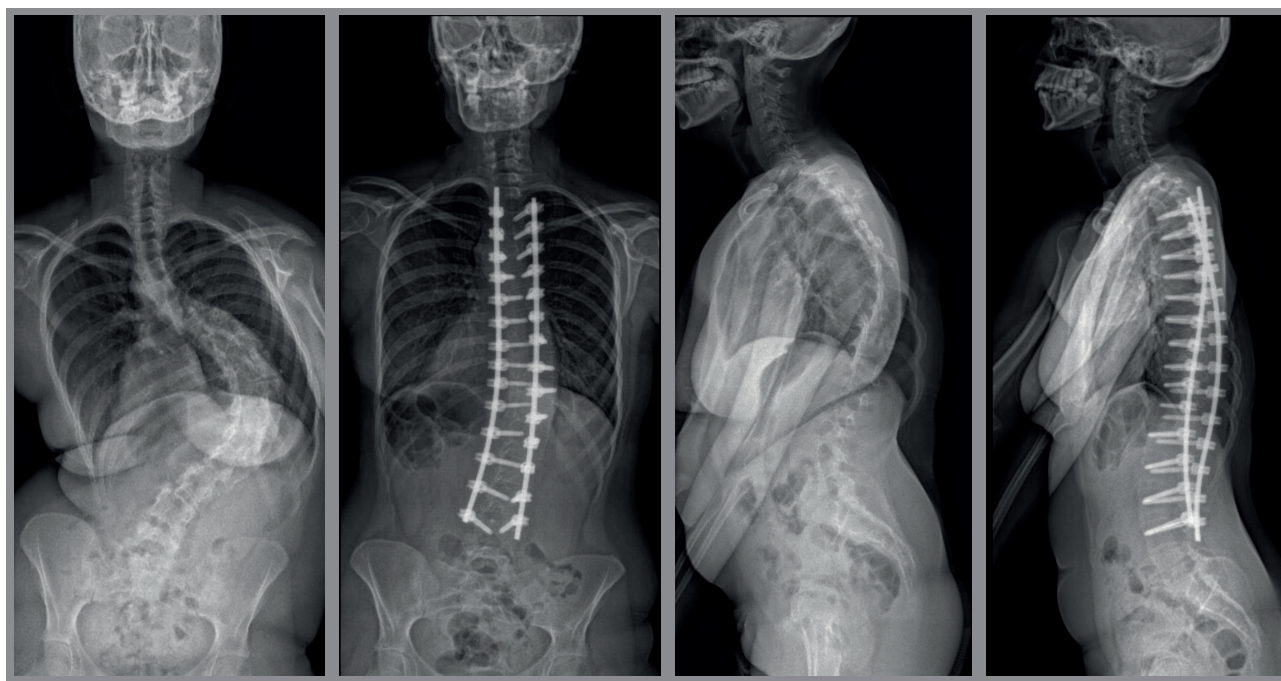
X-rays before and after surgery, Cobb angle 115°.
